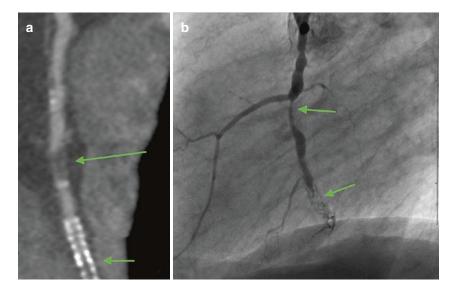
CTA demonstrated multivessel plaques and nonobstructive (less than 40% stenosis) disease. (a) A curved MRP demonstrated greater than 70% stenosis in the right coronary artery 1-2 cm proximal to a right coronary artery stent and greater than 70% obstruction within
